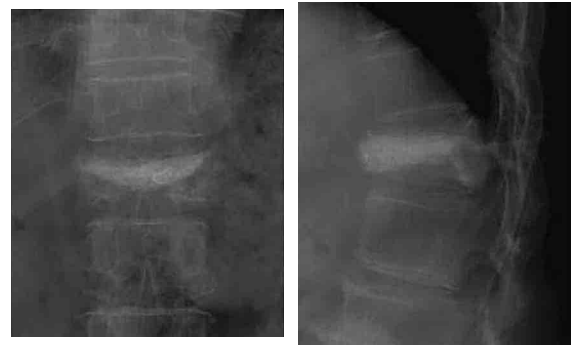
Plain radiographs showing compression fracture of T12 with implantation of PMMA and local kyphotic deformity of the thoracolumbar junction (Cobb angle : 33°).
